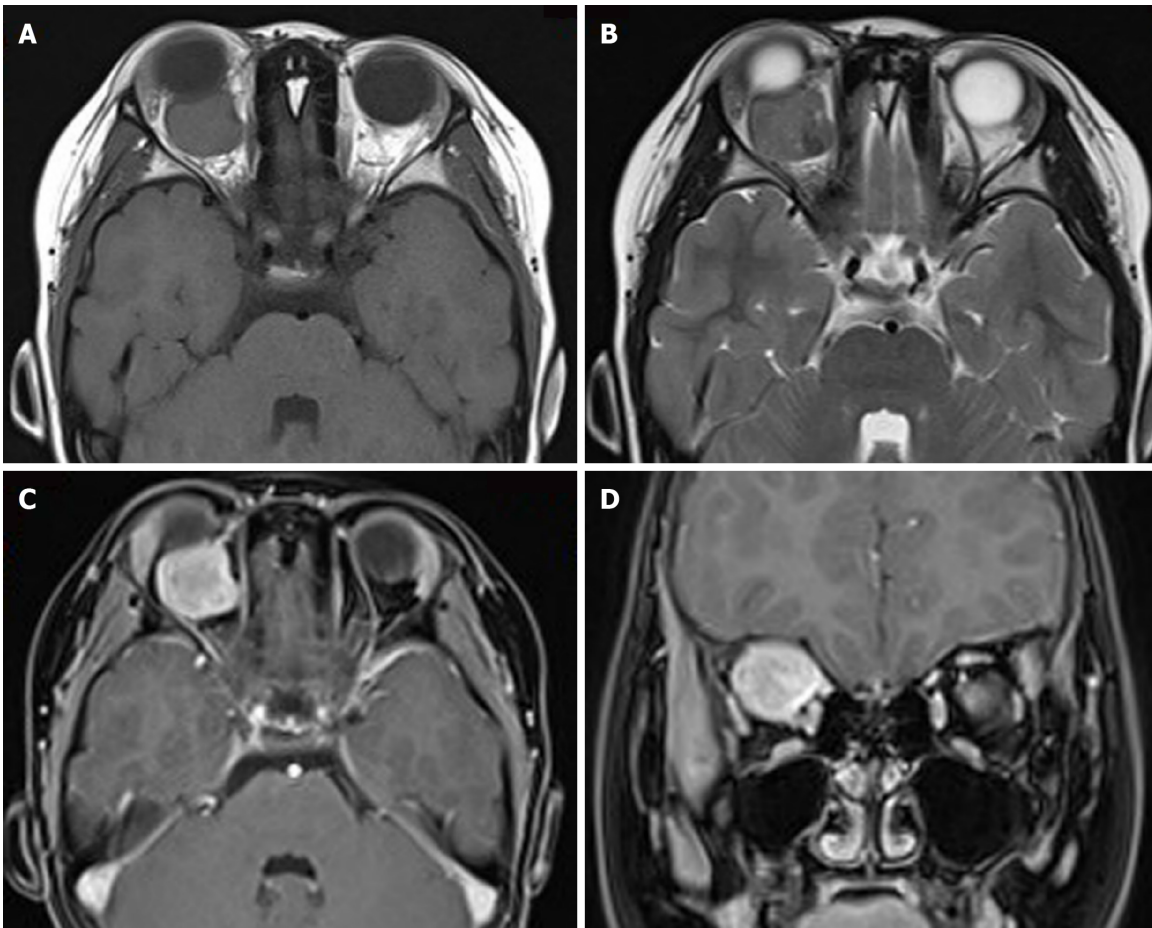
Orbital magnetic resonance imaging showed a circular-like mass in the right orbital. A: T1-weighted images showed moderate signals, mixed with low-signal regions; B: T2-weighted images showed mixed signals, with high number of moderately high signals, and mixed with low-signal regions; C and D: Most part of the lesion was significantly and unevenly enhanced, whereas local lesions did not exhibit any enhancement.
